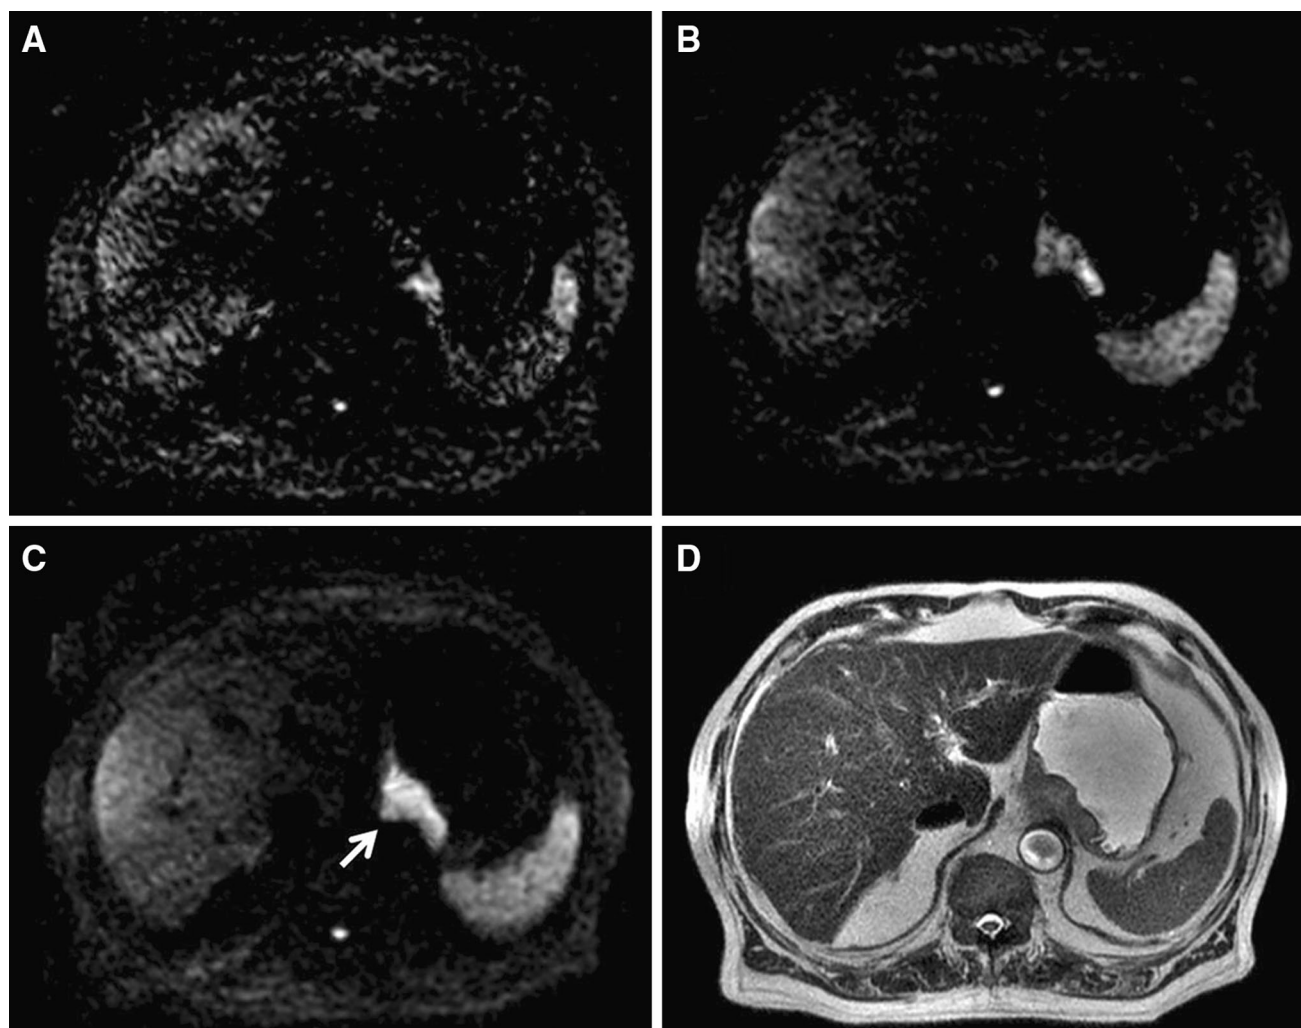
Image quality of DW-MRI sequences with different NEXs. a One NEX. b Two NEXs. c DW-MRI with four NEXs. This showed more uniformity in tumor signals and fewer artifacts than (a) and (b). d Routine MR images of SSFSE.
